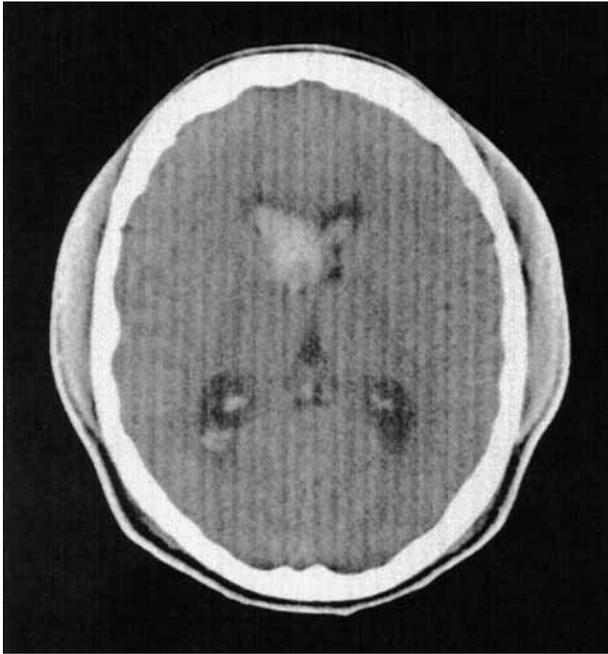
(day of admission) Noncontrast axial CT image of the brain revealed a small round lesion within an intraventricular hemorrhage.
